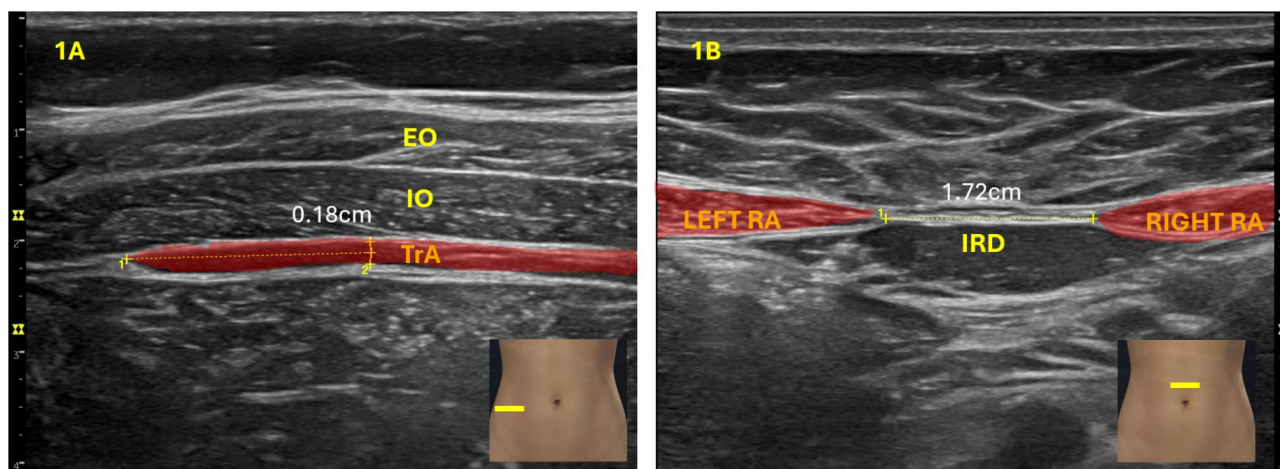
Probe localization and ultrasound measurement of transversus abdominis (TrA) and inter-recti distance (IRD) (1B). Abbreviations: EO, external oblique; IO, internal oblique; RA, rectus abdominis
